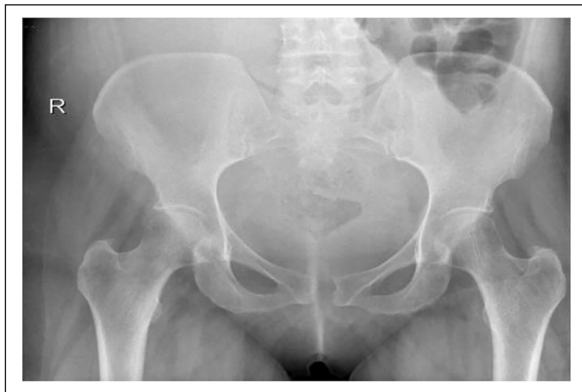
AP plain radiographic of the pelvis and sacroiliac joints revealed minor widening of the symphysis pubis and no other abnormalities.
